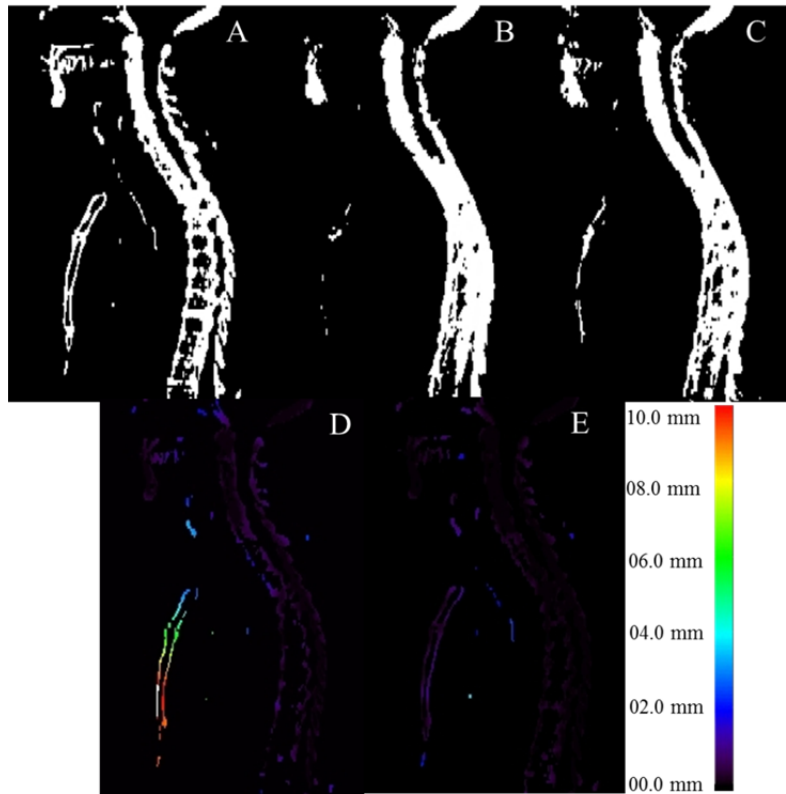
Representative slice of bone segmentation from MR images showing: A) Binary image of segmented bone from CT images, segmented bone using B) Hofmann's technique and C) our proposed SAP approach. Distance error map calculated by comparing Hofmann's technique D) and our SAP approach E) with the reference bone segmented on CT images.
